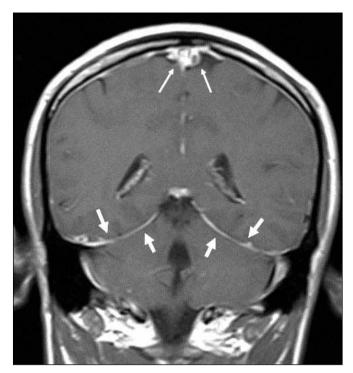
Contrast enhanced T1W Coronal MRI during orthostatic headache episode reveals moderate dural enhancement and thickening in tentorium (thick arrows). Note that venous engorgement can be seen in the superior sagittal sinus (thin arrows).
